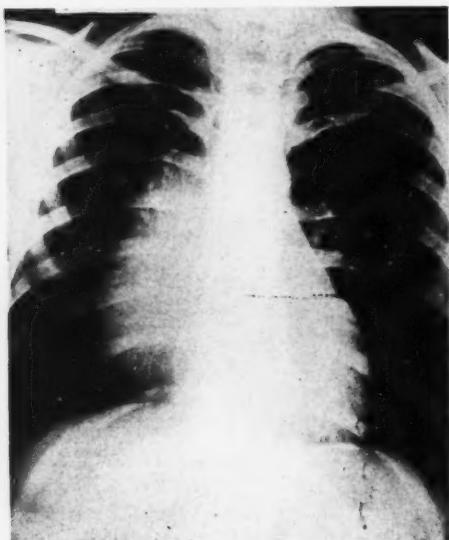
Preoperative posteroanterior roentgenogram of the chest showing an opacity along the right side of the heart, extending from the level of the first anterior rib down to the diaphragm.
